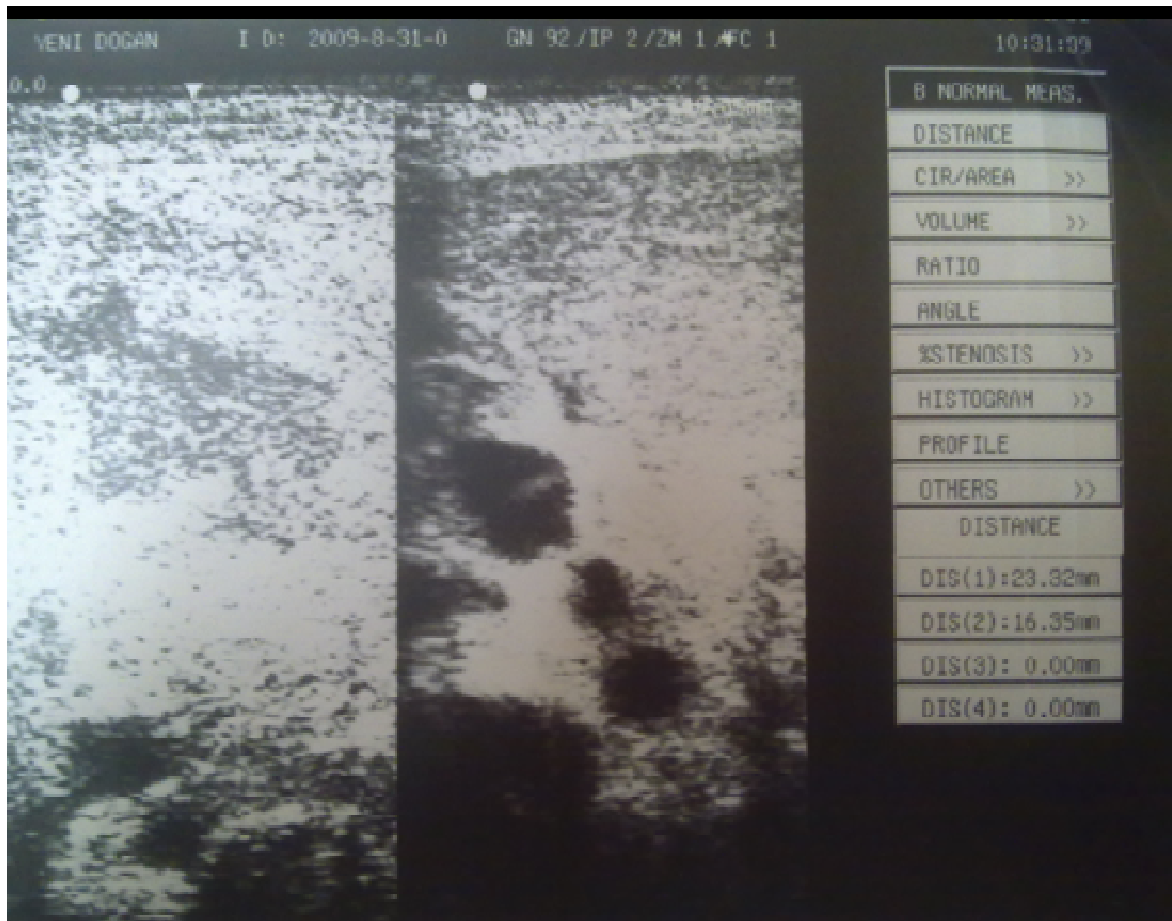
Abdominal ultrasonography finding of the case.
